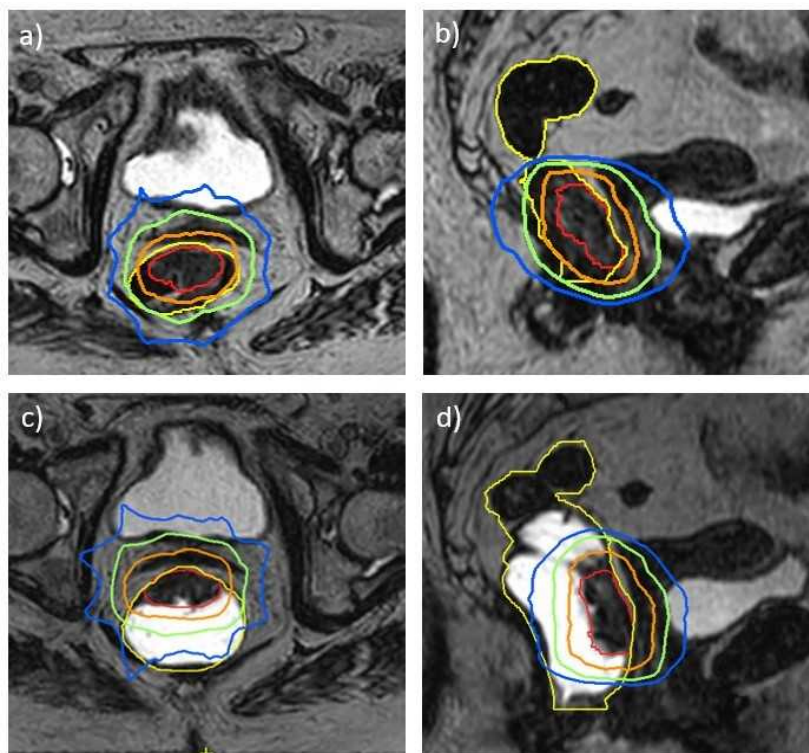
Dose distribution of a 3 Gy boost plan on the 1.5 T MR-Linac without (a and b) and with rectal ultrasound gel filling (c and d). Yellow - rectum, red: primary tumor, orange - 95% Isodose, green - 70% isodose, blue - 50% isodose.
